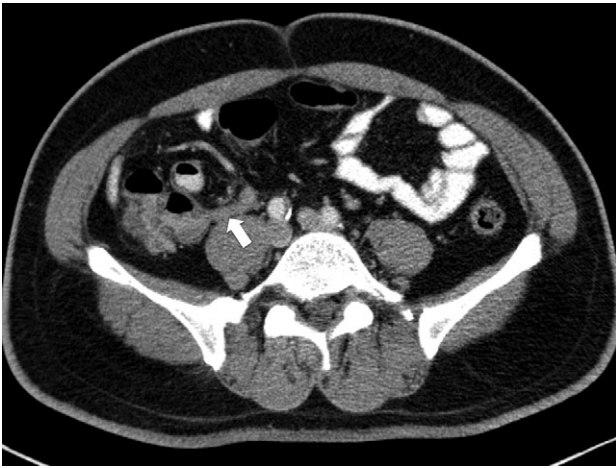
Abdominal CT of Case 1. The appendix is distended and demonstrates surrounding mesenteric stranding (arrow). There is no appendicolith and no free gas or discrete collection to suggest perforation.
